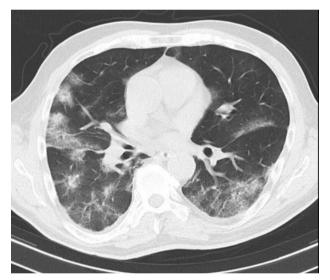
Chest HRCT axial image demonstrating bilateral GGOs.
